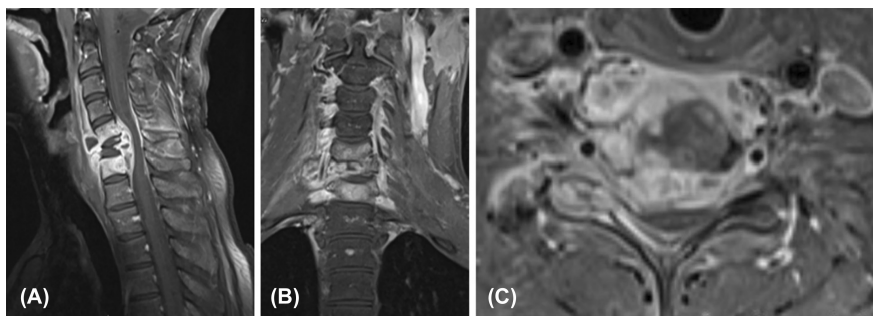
(A) Sagittal image of the spine MRI with T1-weighted contrast. It demonstrates a marked reduction in the height of the C6 vertebral body, with a residual posterior part measuring approximately 4 mm in maximum height. The vertebral bodies of C5, the residual part of C6, and C7 exhibit abnormal mixed signal intensities on T1-weighted MRI, high signal intensity on T2-weighted MRI, and intense contrast enhancement. (B) Coronal spine MRI T1 with contrast image showing the lateral extent of the collection. (C) Axial spine MRI T1 with contrast image demonstrating the intracanal epidural collection causing severe cord compression.
